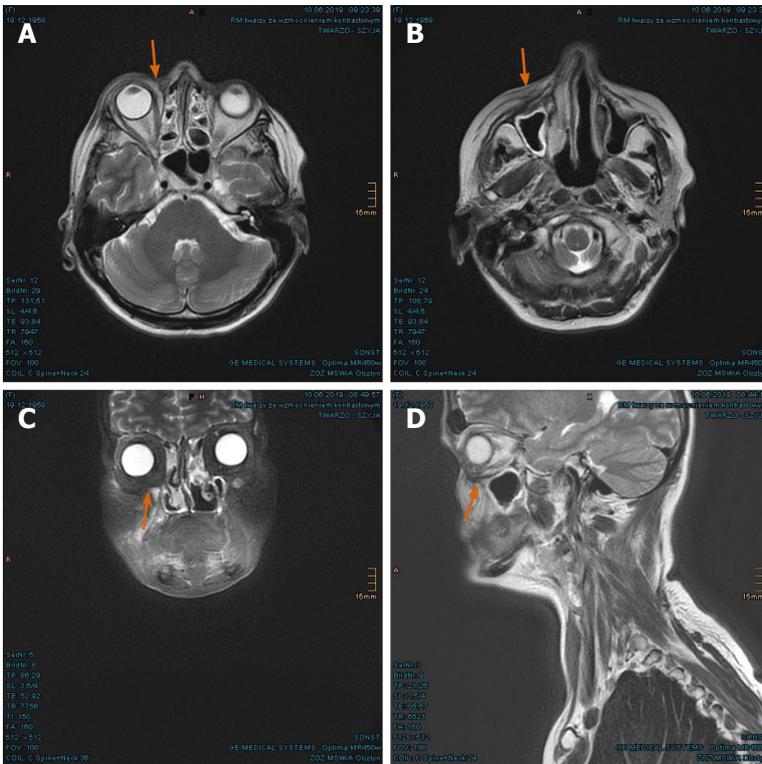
Sustained full remission in the magnetic resonance imaging at 14 mo after proton beam therapy. A: Right naso-orbital corner; B: Maxillary sinus and naso-labial fold; C and D: In coronal and sagittal plane, respectively.
